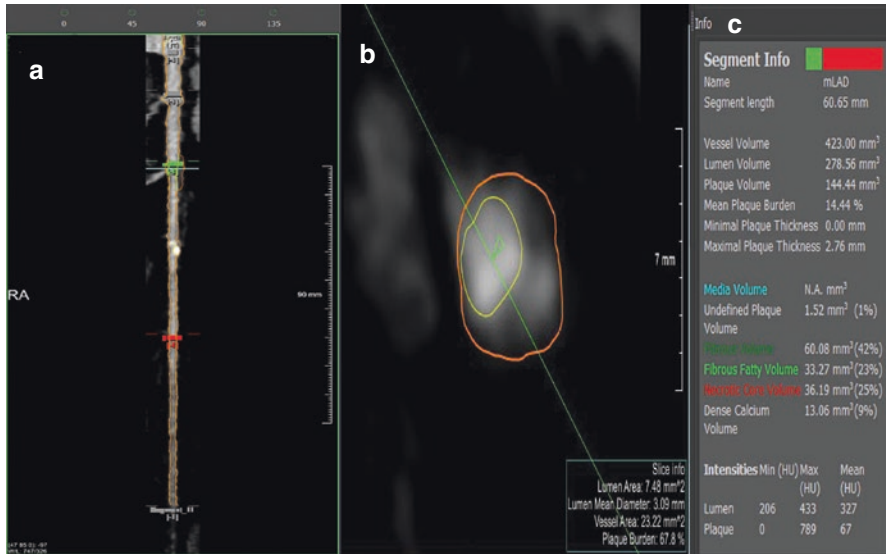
Example of semi-automated plaque analysis (using QAngio CT research edition Medis Specials Version 3.1.4.1) of left main and left anterior descending arteries, showing longitudinal straightened view. (a) Cross-sectional views showing calcified plaque surrounding the vessel lumen (b) and plaque analysis results showing total plaque volume (144 mm³), fibrous fatty volume (33.27 mm³) and mean plaque burden (14.44%) (c)
